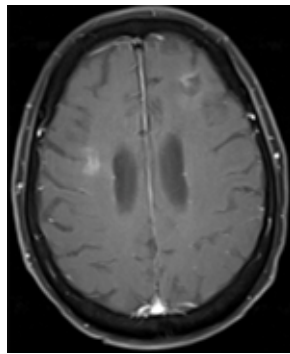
Brain MRI after whole brain radiation therapy. Brain MRI showed a reduction of enhanced lymphoma lesions on post-contrast T1 image after completion of WBRT, at 24 months since diagnosis.
